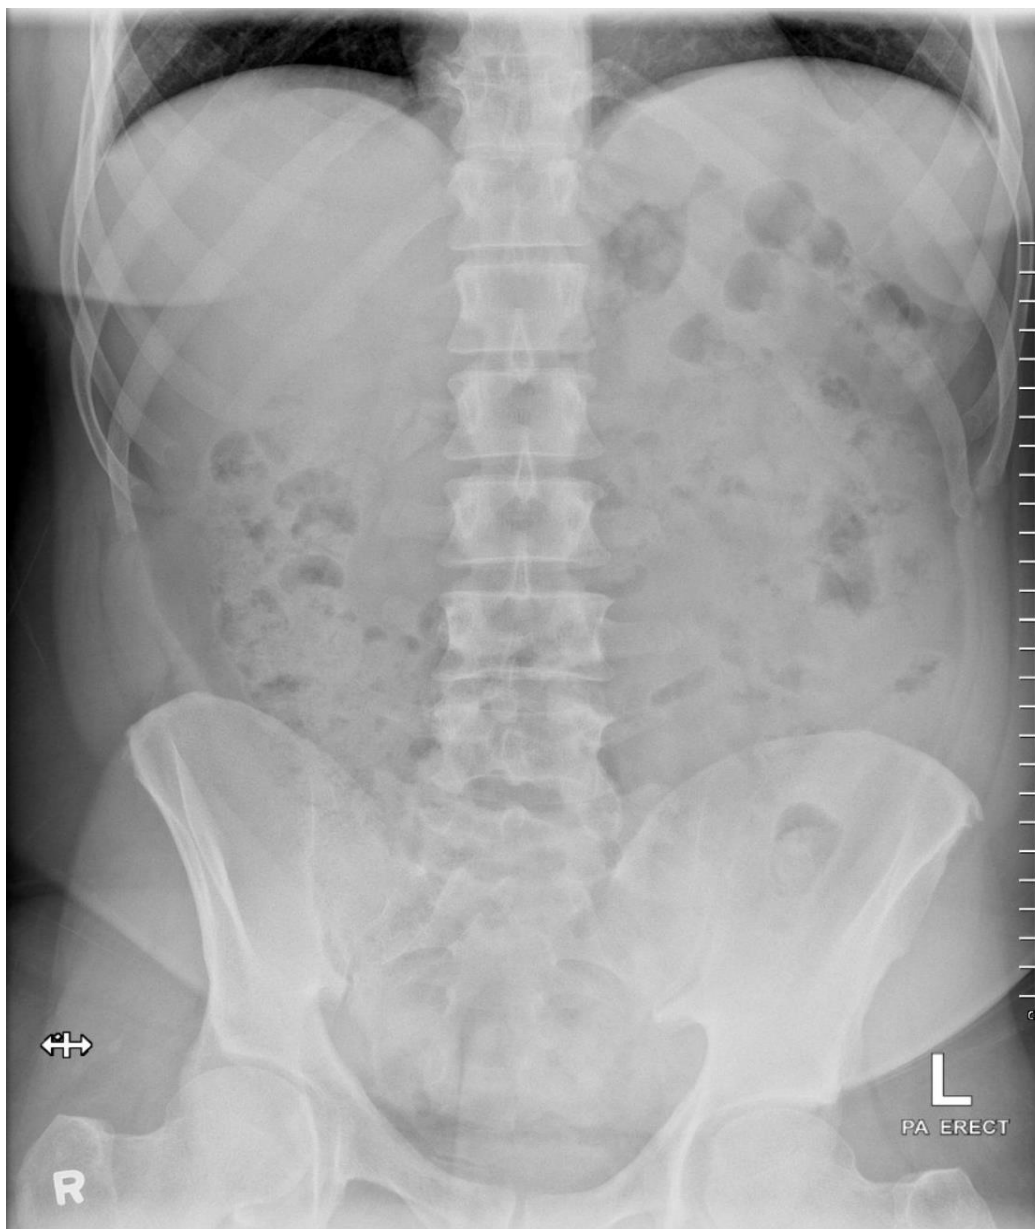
Abdomen radiography had documented only a distension of the intestinal loops, without any signs of sub-diaphragmatic free air
